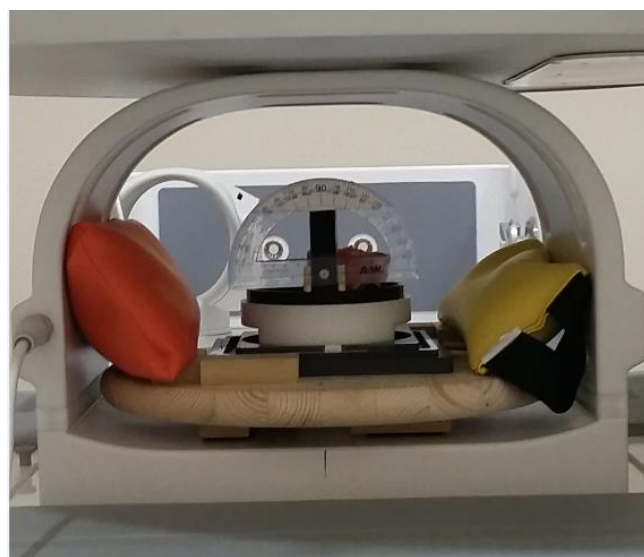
View of the apparatus in the mount attached to the MRI coil with sandbags for stabilizing.
